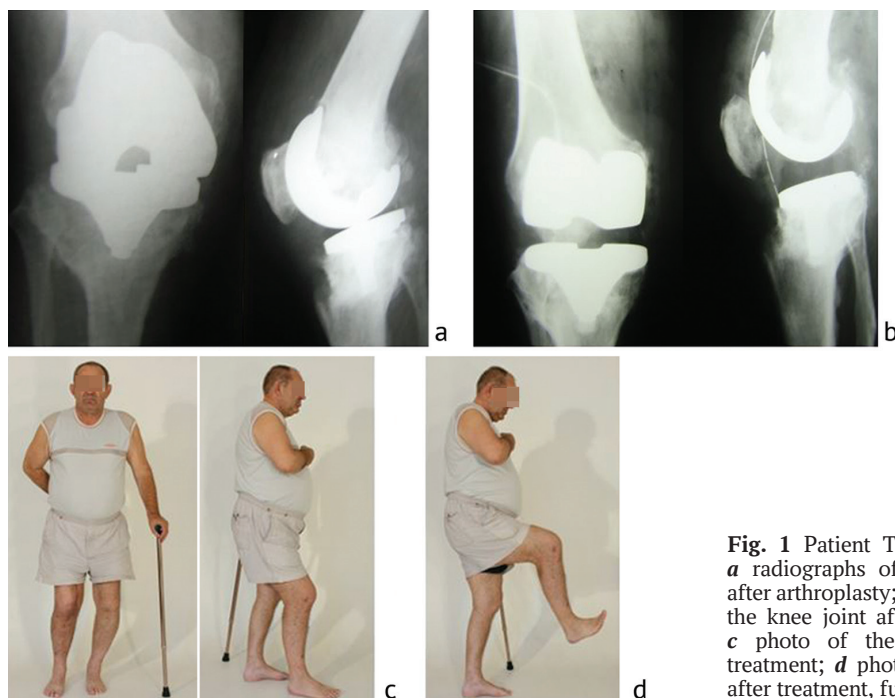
Patient T., 60 years old: a radiographs of the knee joint after arthroplasty; b radiographs of the knee joint after debridement; c photo of the patient before treatment; d photo of the patient after treatment, functional result
